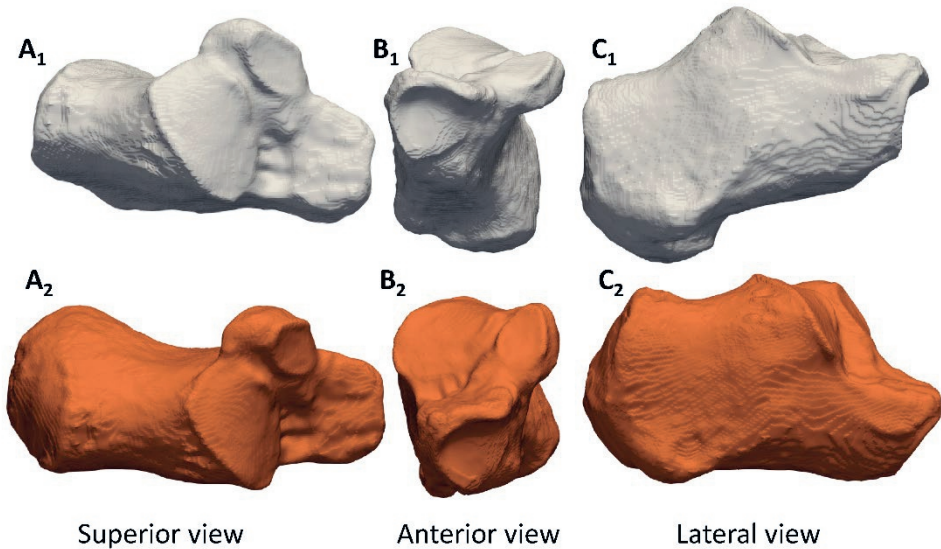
Graphical representation of the right calcaneus of one subject in both coordinate systems. (A) proximal view, (B) anterior view, (C) lateral view. Top row is the calcaneus in the CT coordinate system after aligning the axis of the foot with a sagittal axis. Bottom row is the calcaneus in the coordinate system based on its principal axes (For a better conception of the 3D aspects, the reader is encouraged to consult the interactive 3D figures in the supplementary file (Fig. S-1, doi: 10.1002/jor.24163).
